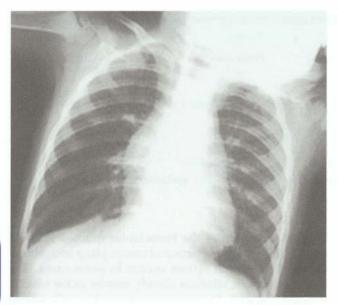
Chest X-ray. Bronchiolitis showing hyperinflation
